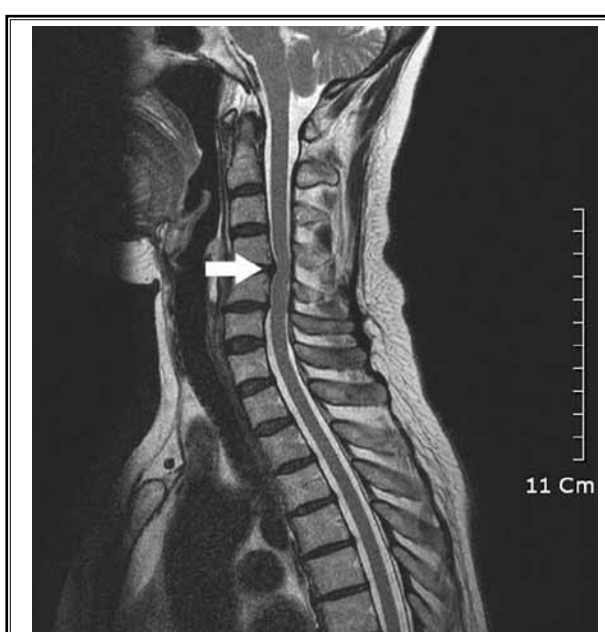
A 55-year-old woman with cervical canal stenosis. Sagittal T2-weighted fast spin-echo image shows grade 2 stenosis at the C4-5 level (arrow). The spinal cord is compressed and deformed but displays no signal changes.
